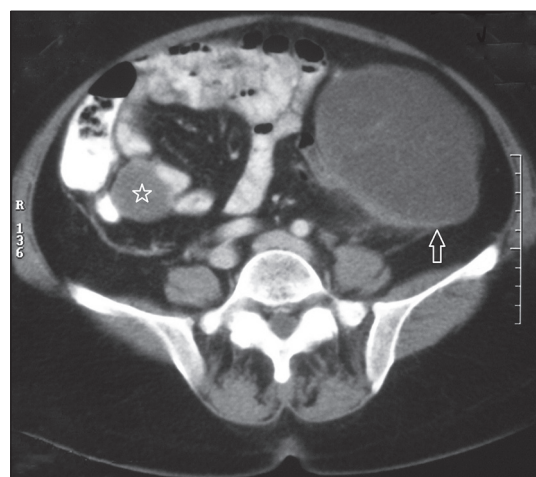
Contrast-enhanced CT scan of the abdomen demonstrating the left retroperitoneal mass (arrow) along with a smaller mass measuring 7×5 cm originating from the ileal mesentery (star)
